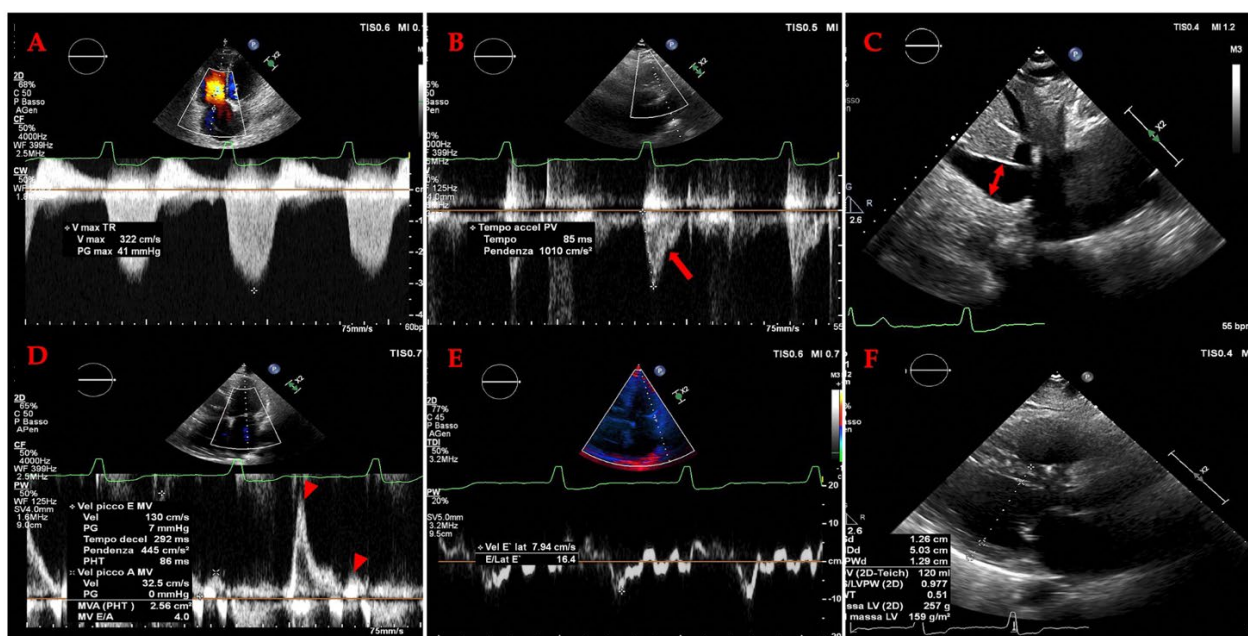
B. Images from the same case described in figure 18A. Signs of elevated filling pressures, pulmonary hypertension, and venous congestion in HFpEF. Note the high E/e' ratio (a sign of elevated left ventricular filling pressure), the restrictive diastolic pattern (panel D) with an E wave much larger than the A wave (arrowheads), the notch on the pulsed Doppler profile of the right ventricular outflow tract with AccT <105 ms (a sign of pulmonary hypertension) (arrow), and the dilated inferior vena cava (panel C) (sign of venous congestion).
